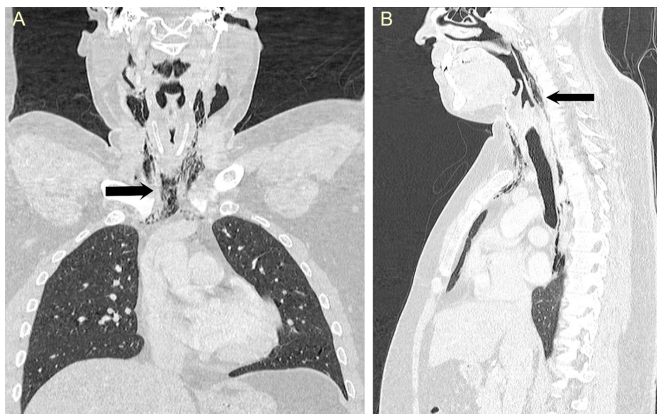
(A and B) Coronal and sagittal CT scan of the neck and thorax showing surgical emphysema within the neck and pneumomediastinum extending from skull base up to T9 vertebra (black arrow).
